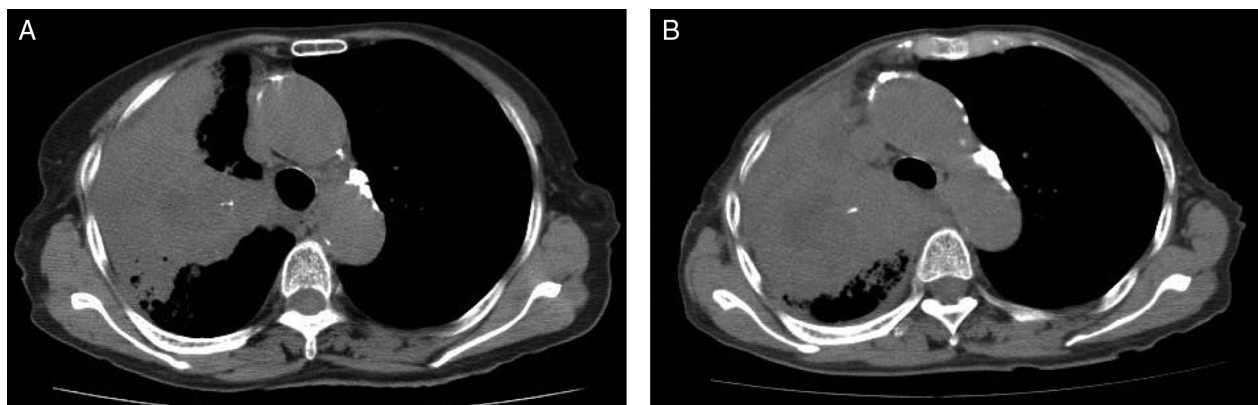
A computed tomography scan on admission showed a large mass surrounded by infiltrates and atelectasis in the right upper lobe (A). Even after gefitinib treatment was started, the tumour mass continued to expand (B).
